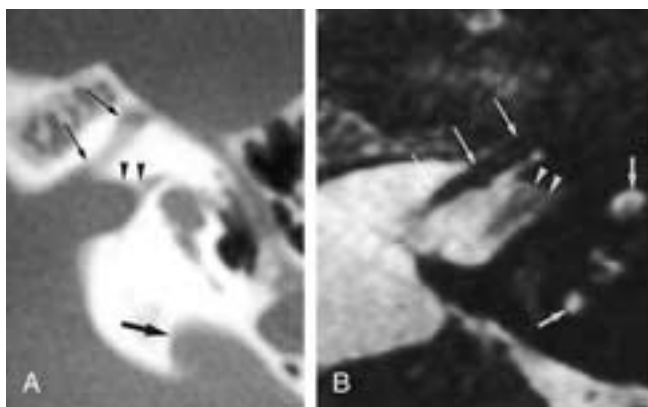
Facial nerve leaving the IAC in its middle one third in a patient with bilateral congenital deafness. A, Axial CT image through the right IAC. The labyrinthine segment of the facial nerve canal (long black arrows) leaves the IAC in its middle one third. Fundus of the IAC (black arrowheads), large vestibular aqueduct (large black arrow). B, Axial T2-weighted gradient-echo image through the right IAC. The facial nerve (long white arrows) can be followed from the IAC into the long labyrinthine segment of the facial nerve canal. Fluid in the fundus of the IAC (white arrowheads) and fluid in the branches of the superior semicircular duct (small white arrows). The presence of CSF between the facial nerve and the walls of the labyrinthine segment of the facial nerve canal, together with the presence of a large vestibular aqueduct on CT, are findings that should alert the examiner to the presence of a gusher ear.
